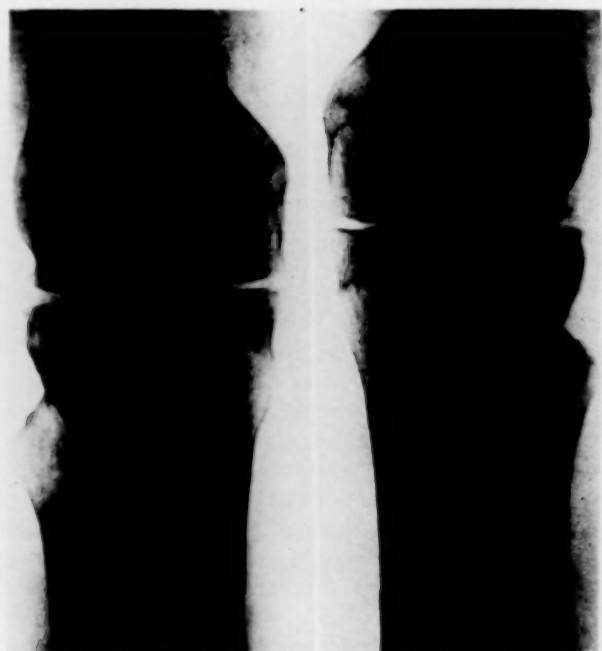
CASE I. Roentgenogram of knees. Note Erlenmeyer flask shape of the proximal ends of the tibias.
